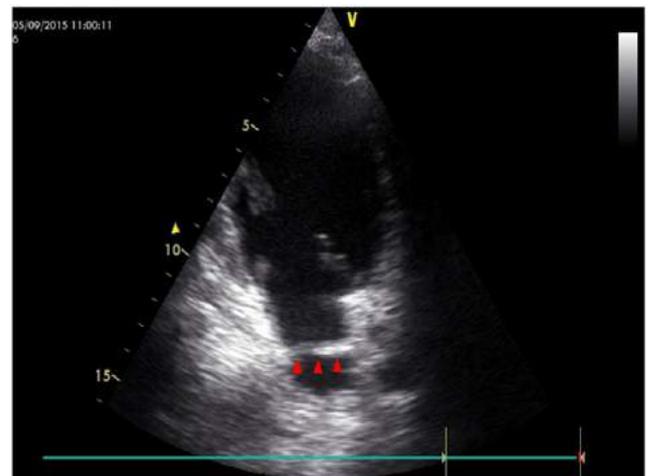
Transthoracic echocardiogram showing left atrial band (arrowheads).
